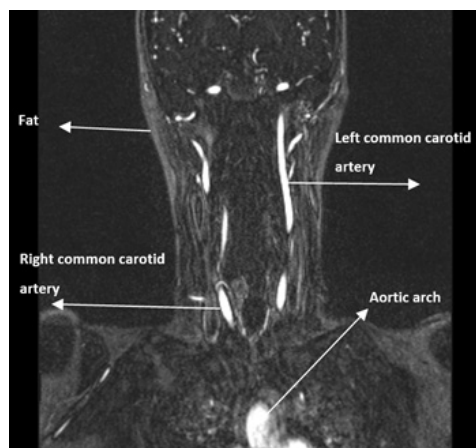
CE-MRA-3D spoiled gradient. Adapted from: (private MRI clinic, 2018).
